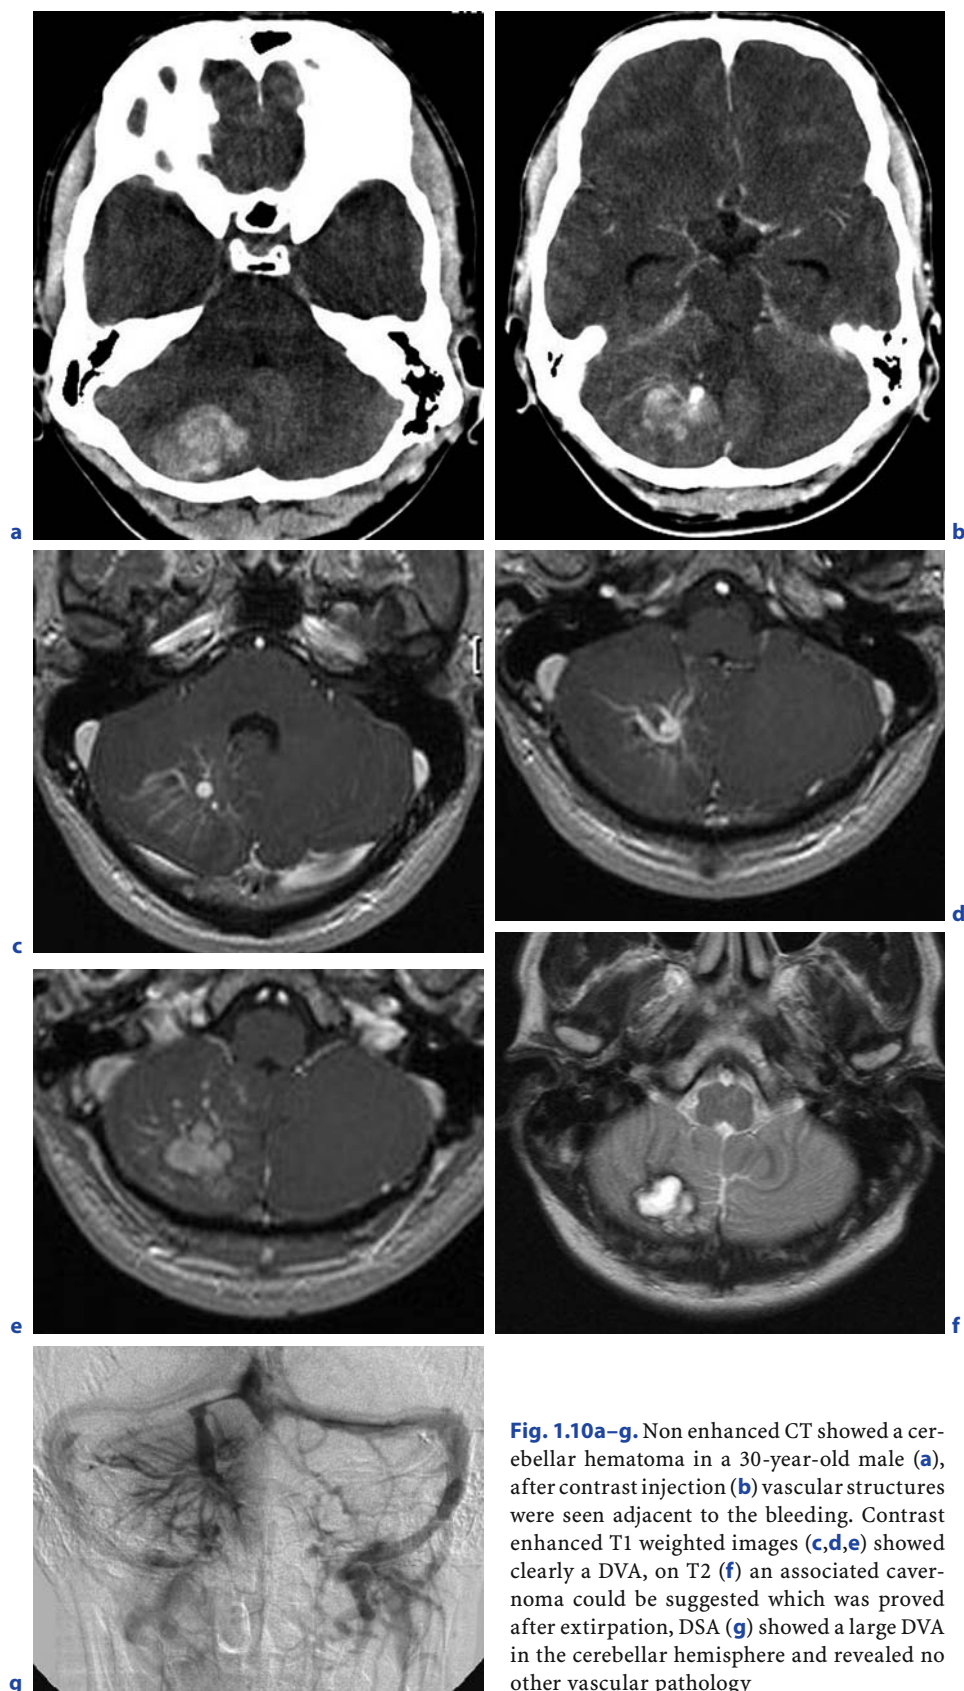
Non enhanced CT showed a cerebellar hematoma in a 30-year-old male (a), after contrast injection (b) vascular structures were seen adjacent to the bleeding. Contrast enhanced T1 weighted images (c,d,e) showed clearly a DVA, on T2 (f) an associated cavernoma could be suggested which was proved after extirpation, DSA (g) showed a large DVA in the cerebellar hemisphere and revealed no other vascular pathology
